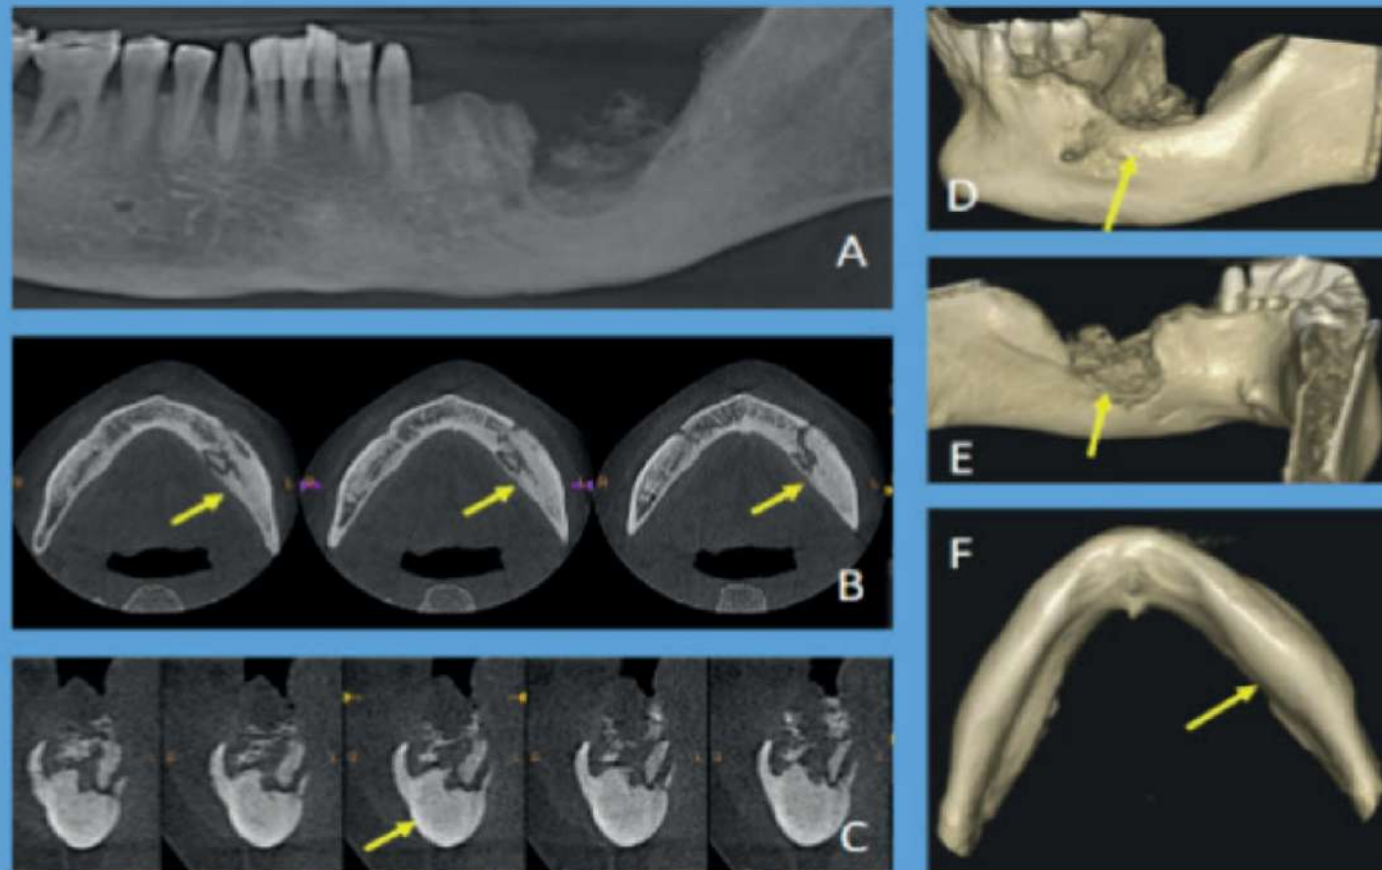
CBCT scan- Panoramic view (A), Axial views (B), crosssections (C) and IVR reveal radiographic features (sequestration, altered density of trabecular bone, cortical expansion, compression of the mandibular canal) of a case of chronic osteomyelitis.
